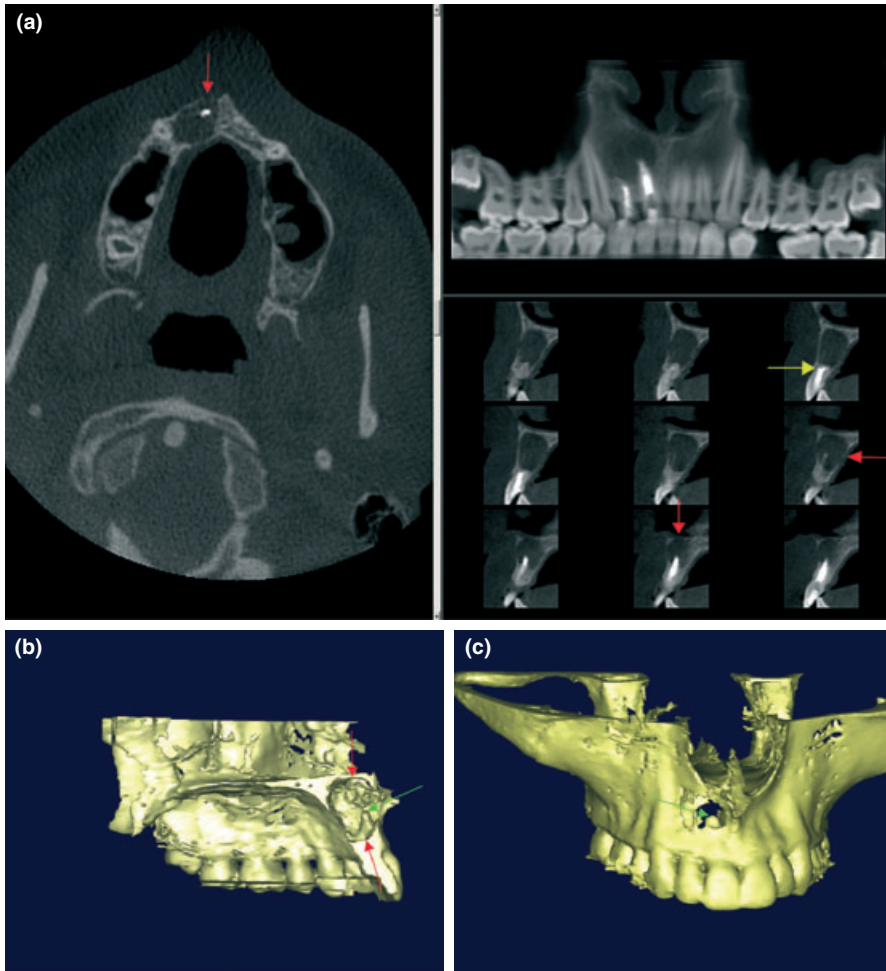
(a) A large volume CBCT scan using the i-CAT scanner. The monitor screen shows reconstructed axial, sagittal and panoramic images simultaneously. All three planes clearly show the full extent of the periapical radiolucency (red arrows) associated with teeth 11 and 12. The sagittal views reveal that the root filling in tooth 12 has perforated through the labial root surface (yellow arrow). (b, c) Three dimensional volume rendered models can be created using specially designed software. It allows the area of interest to be visualized and can be rotated in any angle for viewing: (b) is a sagittal view, (c) is a coronal view. The apical third of tooth 11 (green arrows) and the extent of the lesion (red arrows) can clearly be assessed.
